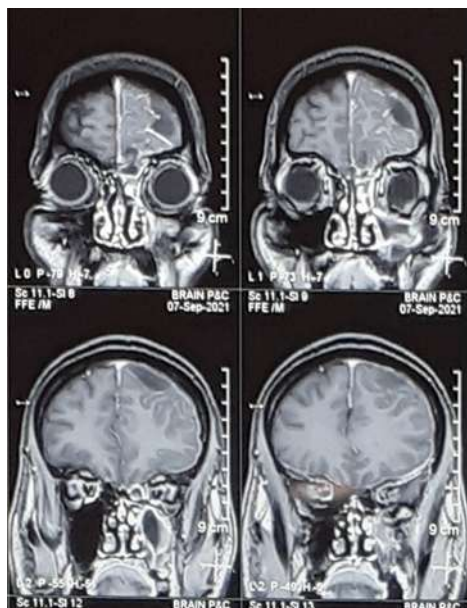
MRI BRAIN DWI showing subdural empyema
